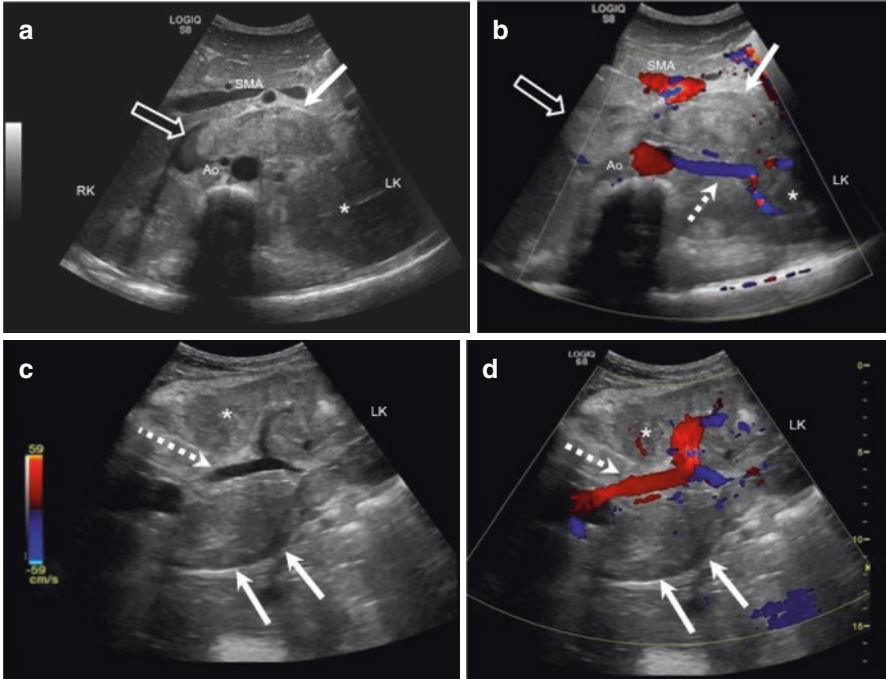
Left renal tumor (*) associated with occlusive hematic thrombosis of the entire left renal vein (white arrows) with extension to the inferior vena cava (black arrows). B-mode US (a, c) and color Doppler US (b, d) images. Axial section of the upper abdomen on (a) and (b), and left renal hilum via lumbar access on (c) and (d). *LK* left kidney; *RK* right kidney
